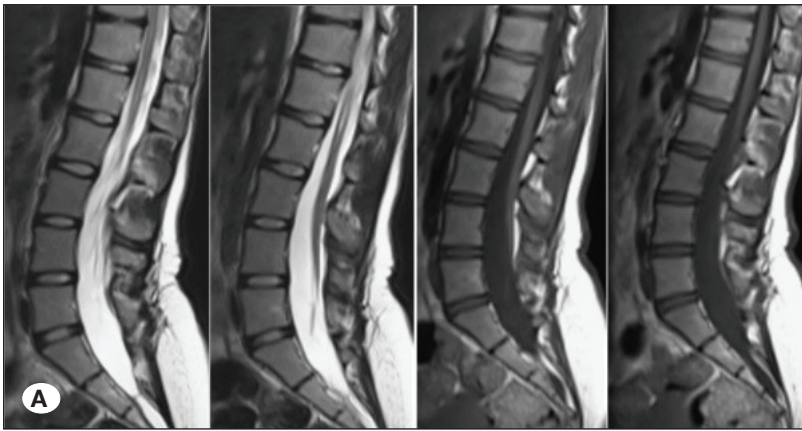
A) A 49 year-old female patient, complaining of pain in the lower back and legs. T2W and T1W sagittal MRI images show the TCS. B) She has no complaints except for mild low back pain in the 5th year postoperative. T2W and T1W sagittal MRI show that the spinal cord position is the same as the preoperative view.
